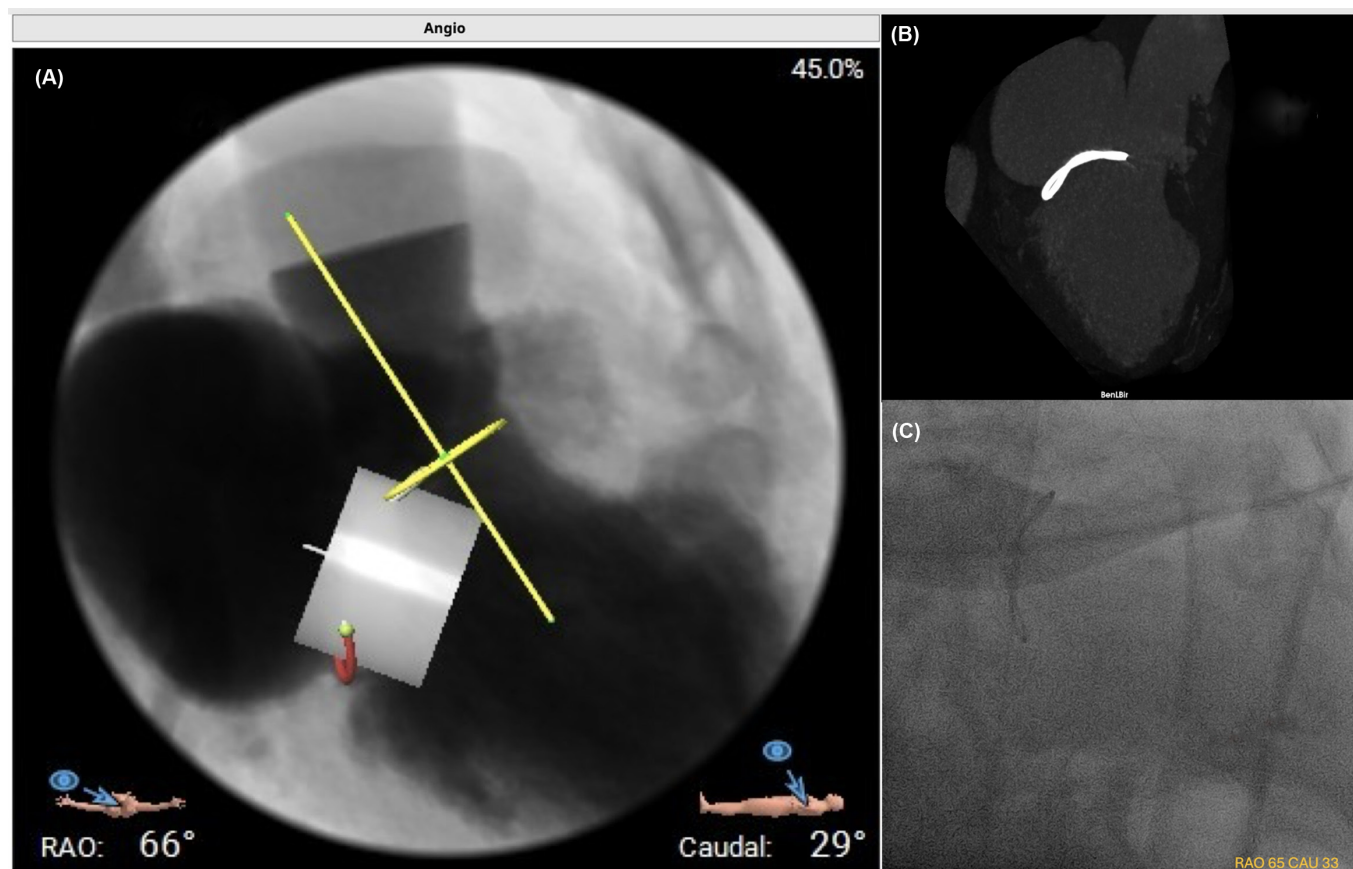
The optimal implantation angle (with the ring viewed in profile) is determined as advanced right caudal based on pre-procedural computed tomography angiography evaluation (A), computed tomography angiography 3D Maximum Intensity Projection (MIP) assessment (B), and fluoroscopy (C), demonstrating consistency across modalities.
